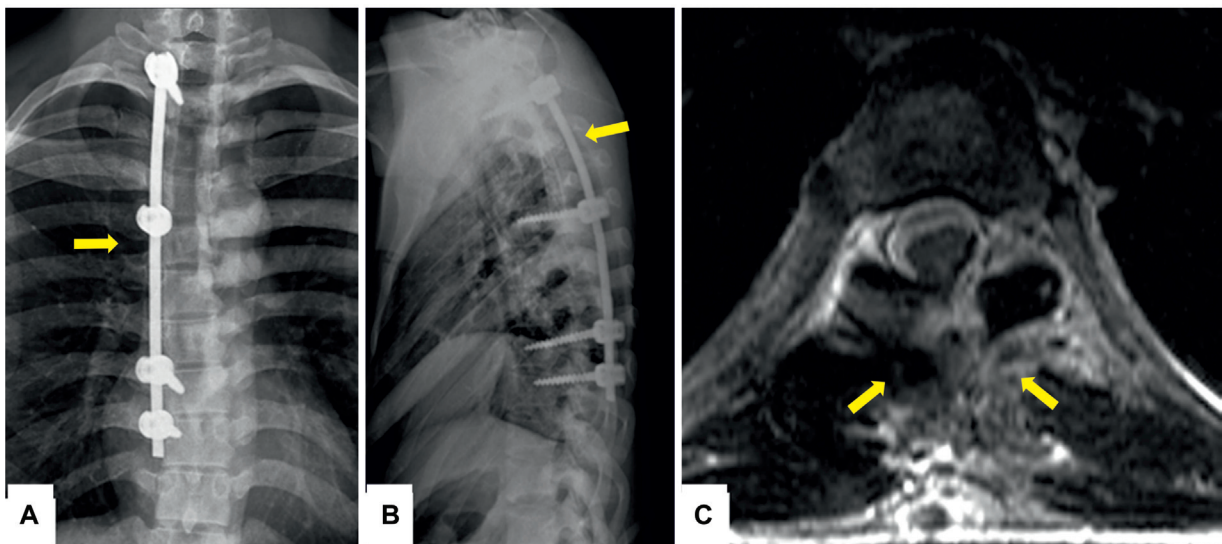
Postoperative anteroposterior radiograph (A) and lateral radiograph (B)—T2 to T9 posterior instrumented stabilization, strategic pedicle screws, and rod (straight arrows). T2-weighted axial magnetic resonance imaging (C)—adequate canal decompression, debulking of lipofibromatous tumor (straight arrow), expansion of the cord.
